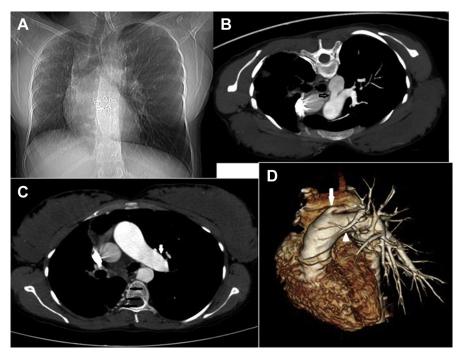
(A) In the posteroanterior chest X ray showing decreased volume of right lung, rightward shift of the mediastinum, right heart enlargement and elevation of the right hemidiaphragm. (B) Axial CT angiography maximum intensity projection (MIP) image demonstrates a PDA (arrow), (C) axial CT angiography image shows absent right pulmonary artery with normal main and left pulmonary artery (white arrow), multiple collaterals from aorta supplying right lung (black arrows). Also, pulmonary trunk was dilated (33 mm), right hemithorax and right lung were smaller than the left ones. (D) 3D volume rendered images show absent right pulmonary artery (black arrow) with normal main (white arrow) and left pulmonary artery (arrowhead).
